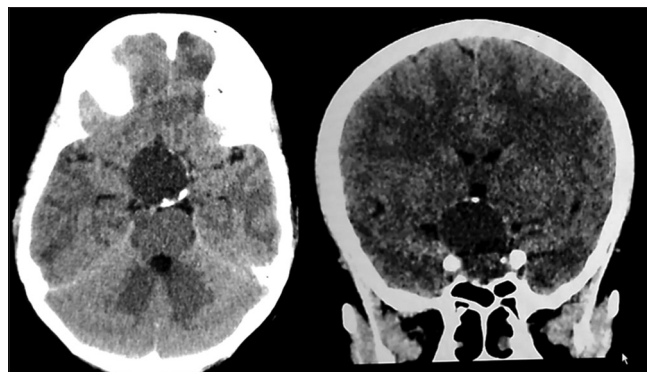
Plain computed tomography scan showing a globular, well-defined hypodense lesion in sellar and suprasellar area with wall calcification
